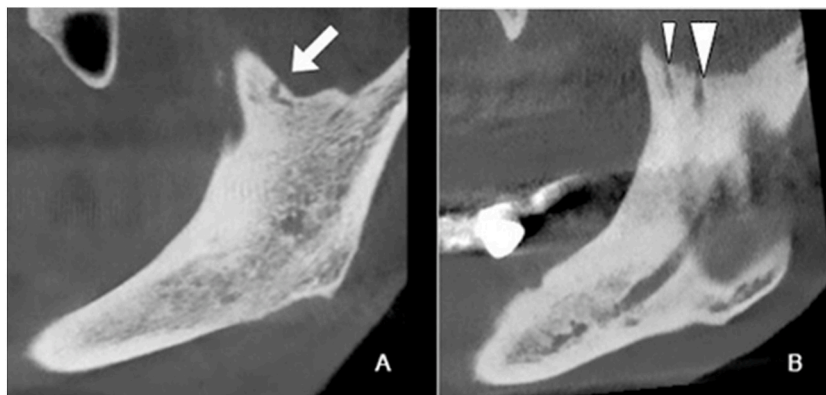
CBCT sagittal section image of coronoid foramen in A, CBCT sagittal section image of coronoid canal in B.
